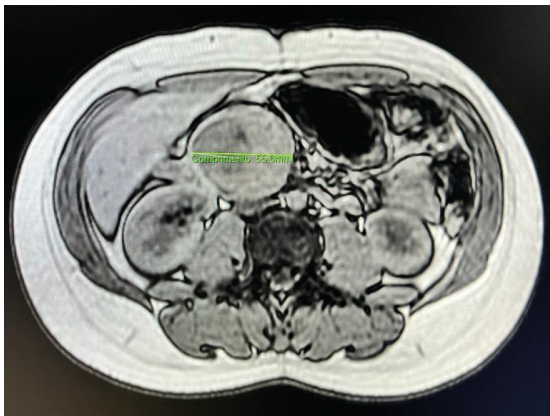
Abdominal MRI showing Frantz's tumor in the head of the pancreas, measuring 55.6mm in its longest axis.
